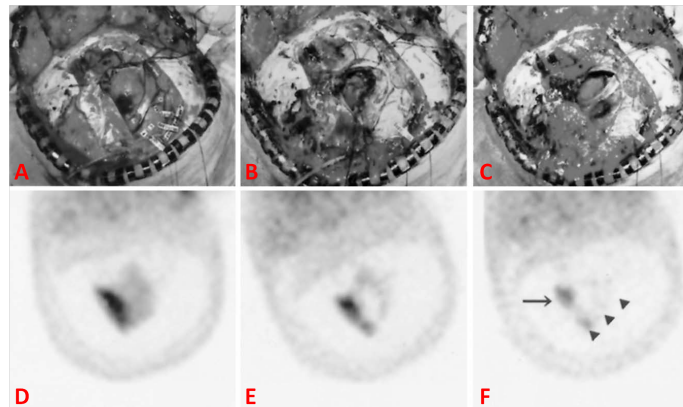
Example of a brain surgery using the aid of an intra-operative gamma camera and MIBI systemic labeling. (A) and (D) show the tumor situs and the intra-operative scintigraphy before the operation. (B) and (E) show the image during the procedure and (C) and (F) the final status, where still tumor tissue remains on the borders of the resection (arrows). Figure taken from [170] and reproduced with permission from Elsevier.
